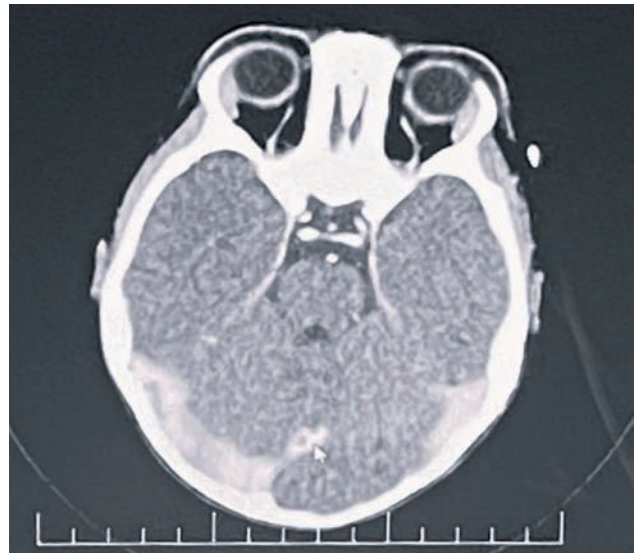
Cerebral CT scan
